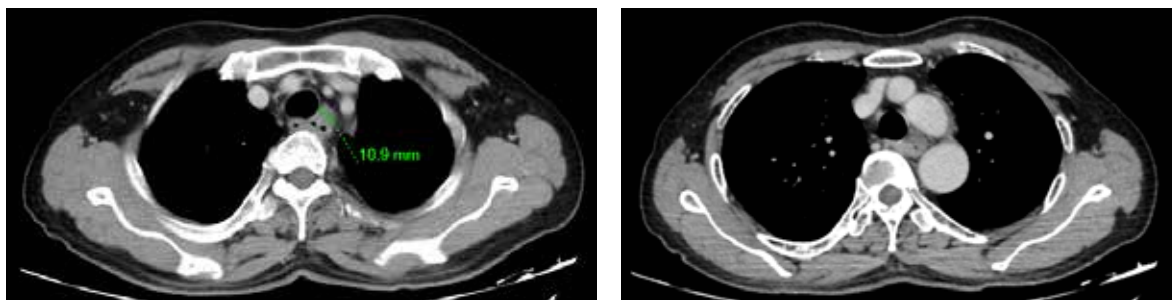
CT scan after two cycles of EP chemotherapy
